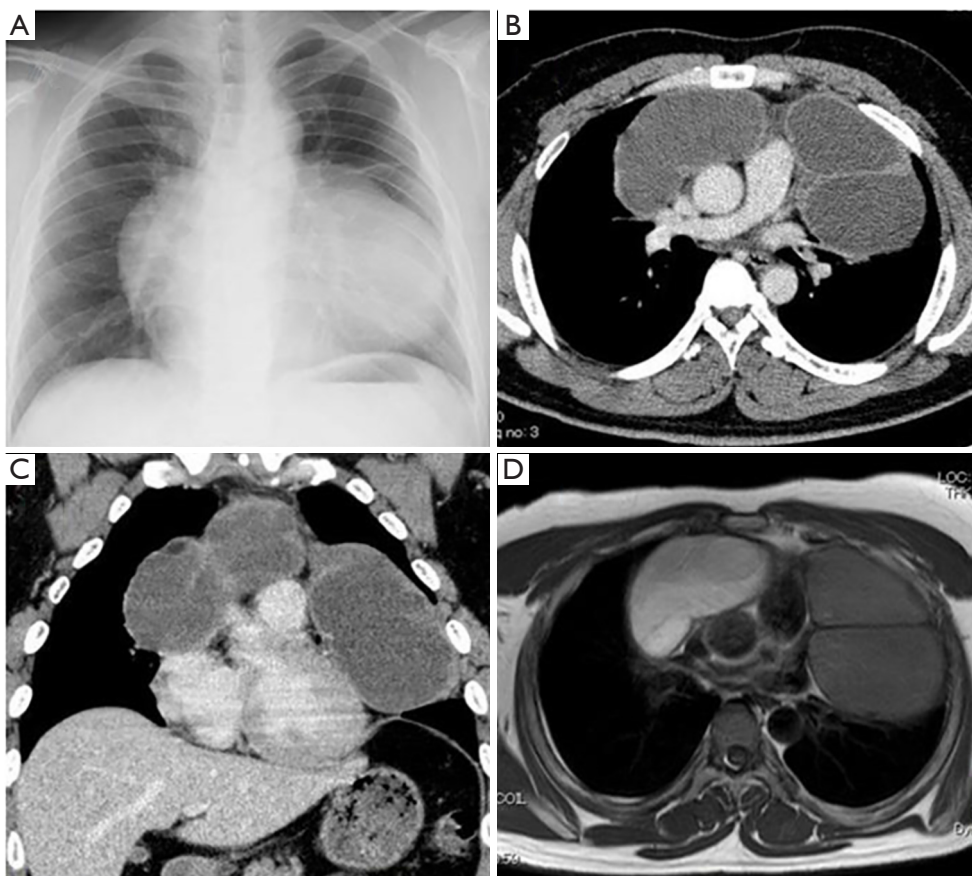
Radiologic examinations revealed two large cystic tumors composed of different contents in the anterior mediastinum. (A) Chest radiograph imaging demonstrating a huge mass adjacent to the cardiac shadow; (B,C) axial (B) and coronal (C) contrast-enhanced CT scans of the chest showing two large cystic tumors in the anterior mediastinum with both sides extending to the midline, especially to the left hemithorax; (D) magnetic resonance imaging scan of the chest (transverse T1-weighted images) demonstrating two huge cystic tumors composed of different contents. CT, computed tomography.
